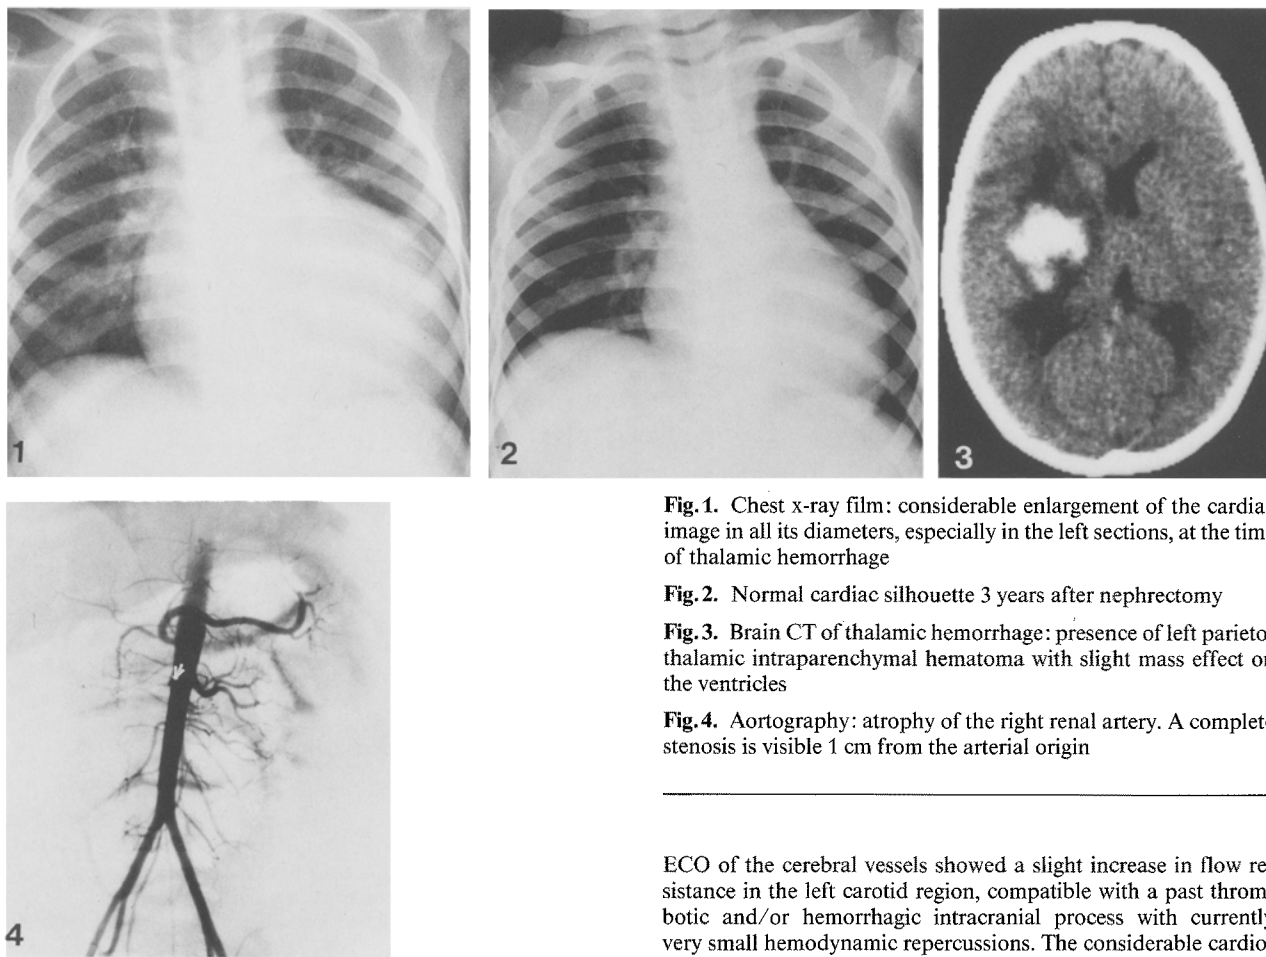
Chest x-ray film: considerable enlargement of the cardiac image in all its diameters, especially in the left sections, at the time of thalamic hemorrhage
